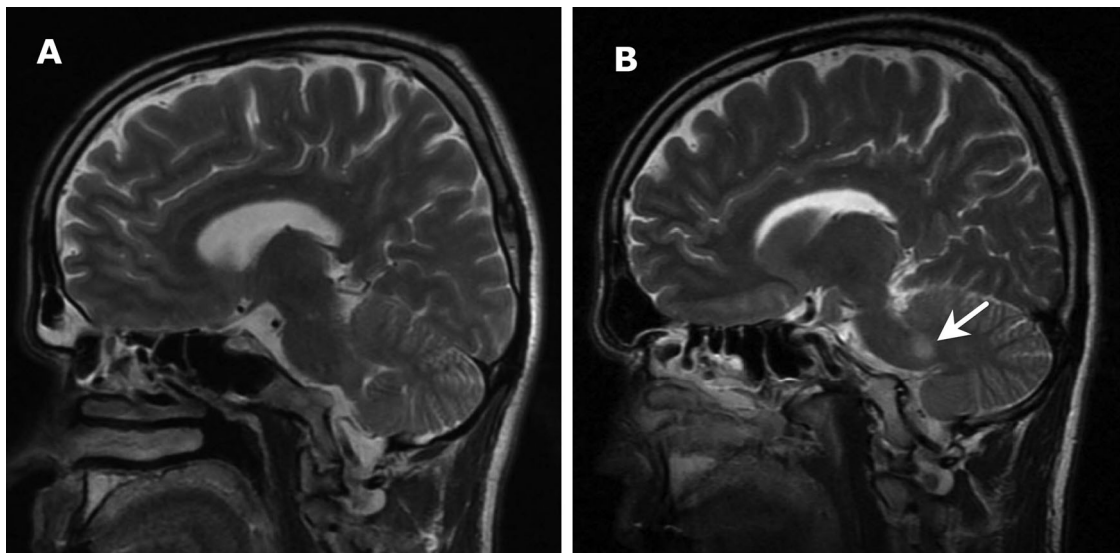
Sagittal T2 weighted brain MRI in September 2019 (A). Sagittal T2 weighted brain MRI in January 2020. The responsible demyelinated lesion of the vestibular nucleus is observed on the left side (B).
